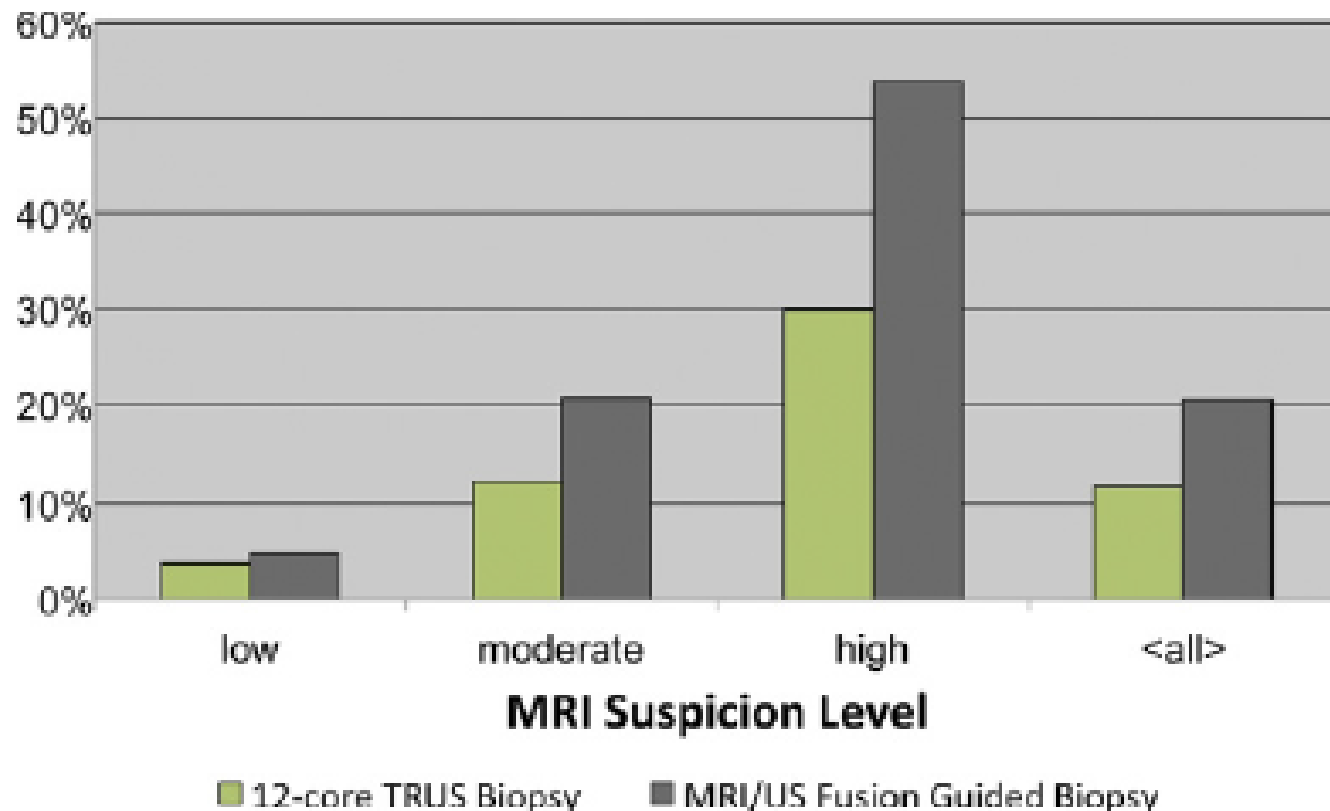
Cancer detection rates for biopsy cores were compared between standard 12-core TRUS biopsy alone and MRI/US fusion guided biopsy alone.
